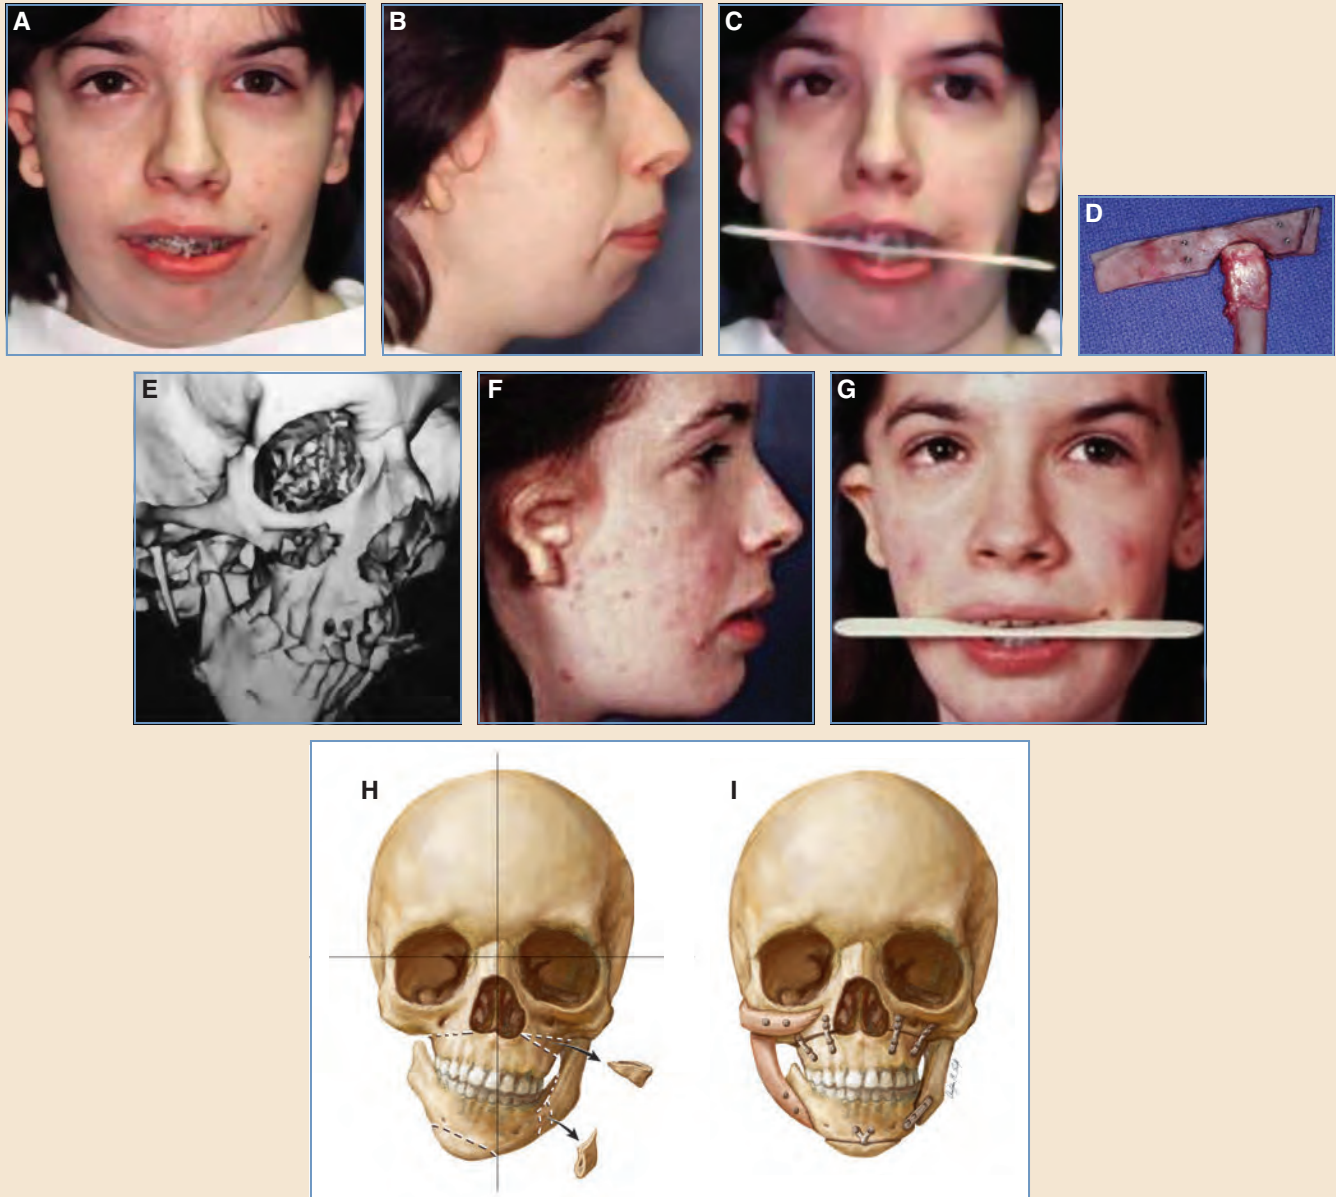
This patient with right CFM (Pruzansky grade III) underwent an asymmetrical LeFort I osteotomy, a left sagittal split osteotomy of the ramus, and a right rib graft and fibular reconstruction. A-C, Preoperative views showed occlusal cant and right-sided maxillary and mandibular deficiency. D, A fibula and rib graft for right mandibular reconstruction. E, A three-dimensional CT scan demonstrated the right-sided deficiency. F and G, Postoperative views show improved symmetry and correction of the occlusal plane. H and I, The reconstruction included asymmetrical osteotomies and graft placement.
